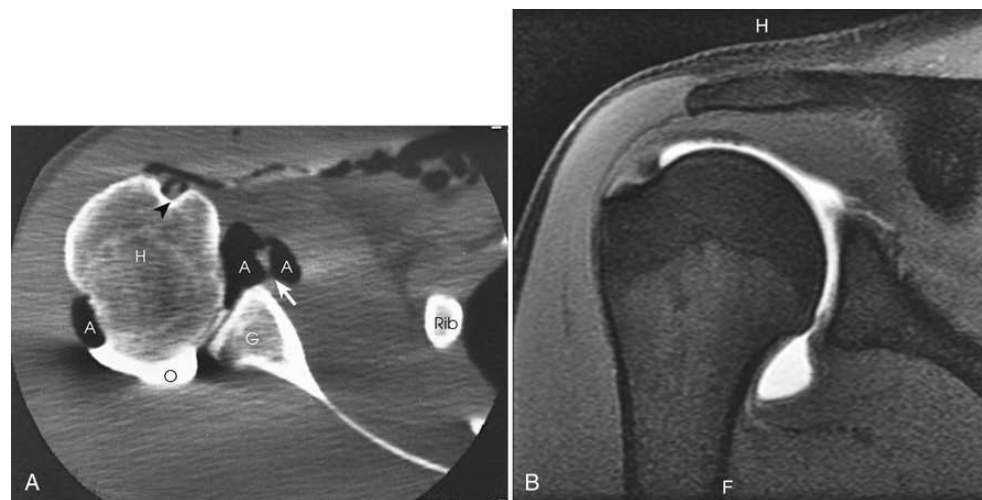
(A) CT shoulder arthrogram. Radiographic arthrogram in this patient was normal (see Fig. 13.5). CT shoulder arthrogram shows small chip fracture (*arrow*) on the anterior surface of the glenoid cavity. Head of humerus (H), air surrounding biceps tendon (*arrowhead*), air contrast medium (A), opaque contrast medium (O), and glenoid portion of scapula (G) are evident. (B) MRI arthrogram of shoulder with injection of gadolinium contrast medium.
